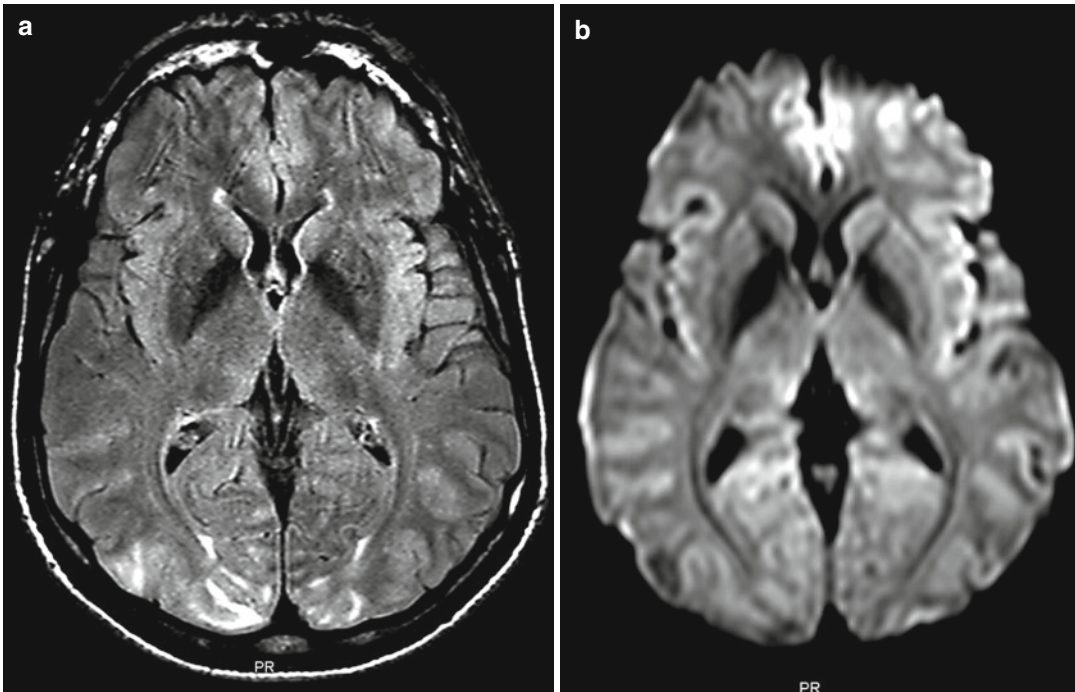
Posterior reversible encephalopathy syndrome. Clinical: Cortical blindness developing after hypertensive crisis. The occipital FLAIR images show increased signal
